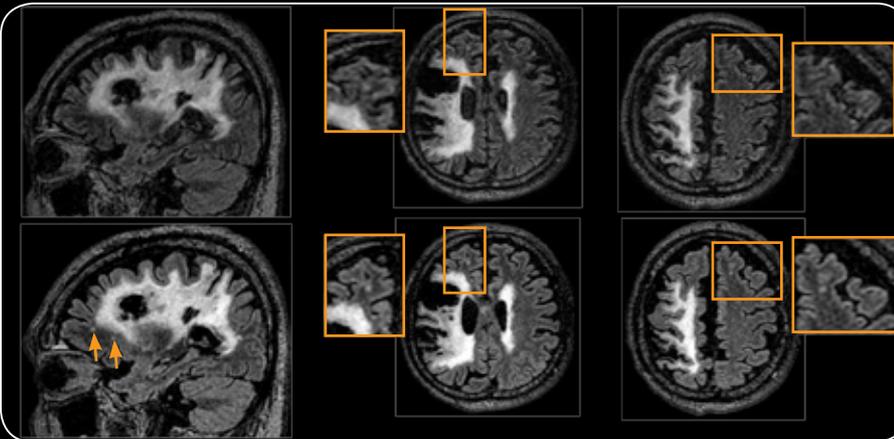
Cube T2 FLAIR images of patient from CHR Laennec Imaging Center, Creil, France using a MR450w. Patient motion with conventional Cube sequence will usually result in artifacts that can mask important findings (top row); incorporating PROMO into the protocol helps reduce the need for rescans and gives higher confidence no anatomy is missed.
